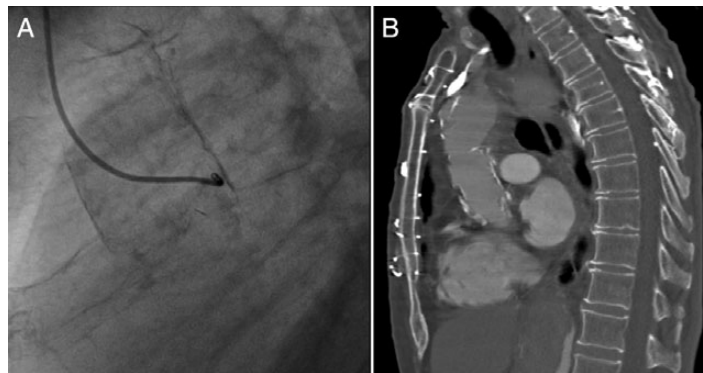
Severely calcified Shelhigh-conduit in (A) angiography and (B) computed tomography.
